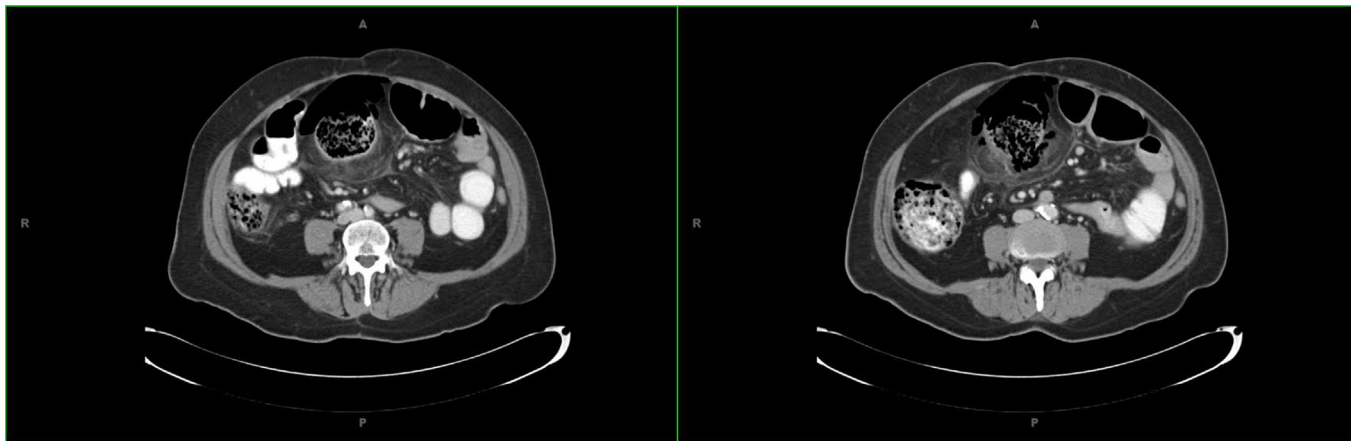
Preoperative CT scan of the abdomen and pelvis showing a large central mass with inflammation and evidence of contained perforation.
